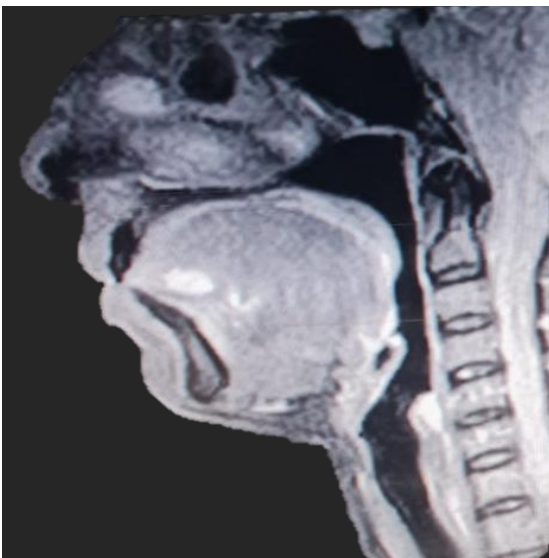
Characteristics of the contrast-enhanced magnetic resonance imaging hypointense nodular lesion in T1 sequence, and intense in STIR and T2 sequence, approximately 11 mm to the side of the midline in the anterior and basal part of the tongue, where homogeneous images with well-defined and encapsulated margins are shown.
